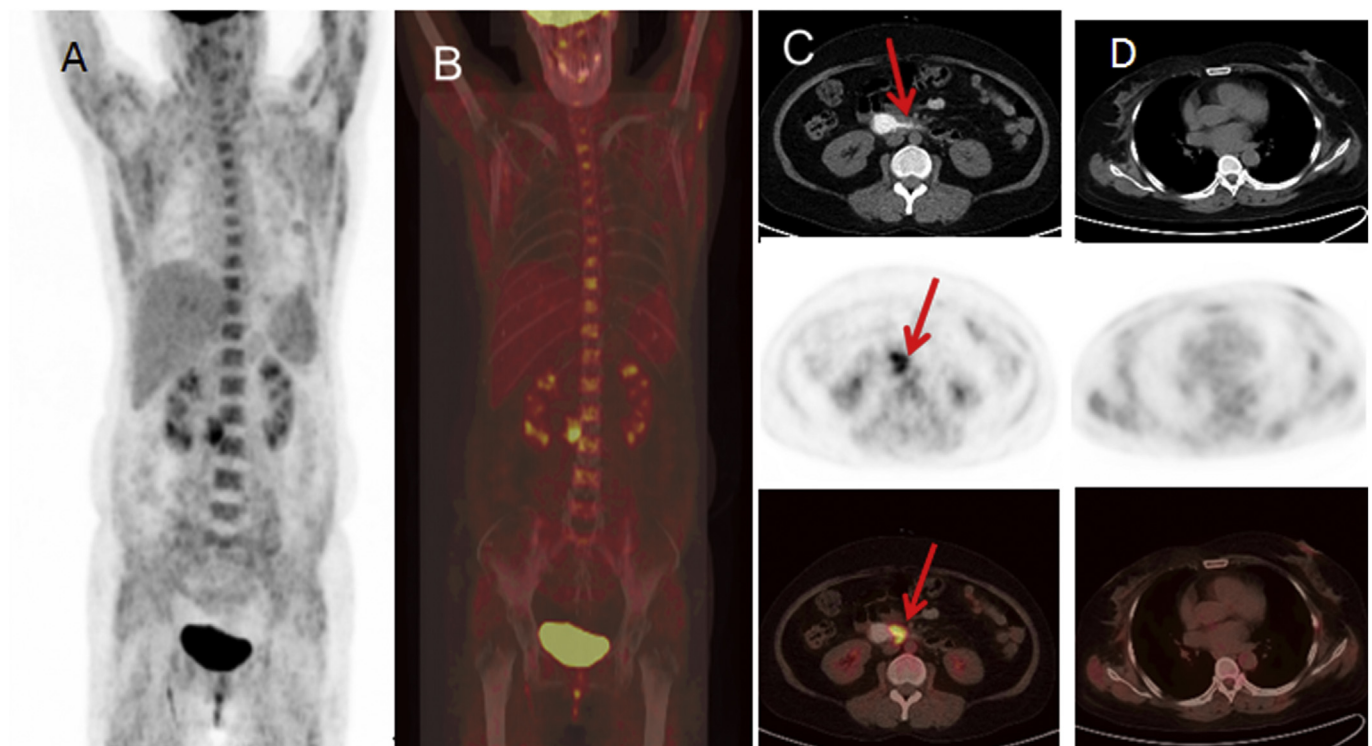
A 47-year-old female was diagnosed with dermatomyositis (Table 1, No 17). A-B, PET/CT maximum intensity projection images showed increased ^{18}F -FDG uptake in muscles. C, Duodenal local bowel wall thickening and luminal stenosis can be seen with marked ^{18}F -FDG uptake (arrow). D, No abnormal density lesions or abnormal ^{18}F -FDG uptake was found in bilateral breast. The pathologic diagnosis revealed that: (1) The lesion in duodenum with marked ^{18}F -FDG uptake was caused by chronic inflammation of the duodenal mucosa; (2) Invasive ductal carcinoma of the left breast was confirmed by surgery.
